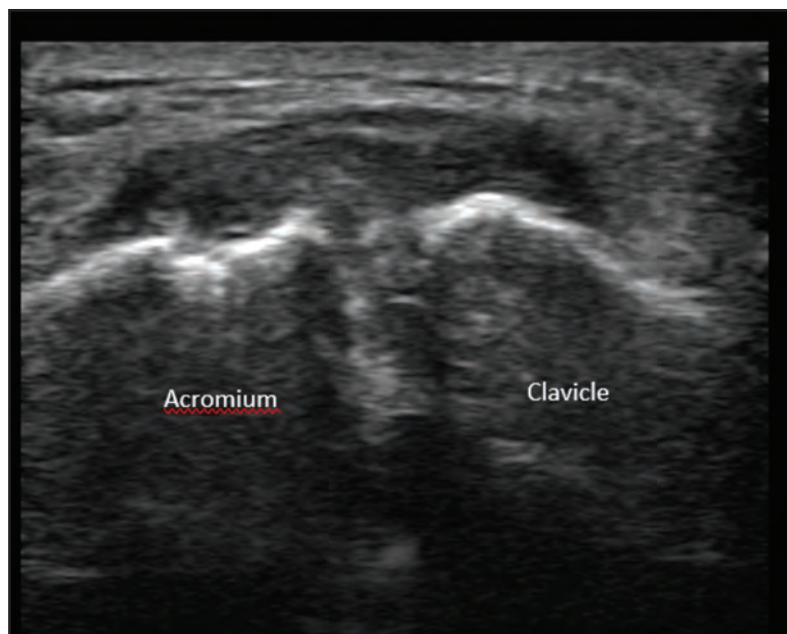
Bedside sports ultrasound demonstrated a large, well circumscribed swelling overlying the superior and anterior aspect of the acromioclavicular joint suggesting a possible effusion with mixed echogenic substance enclosed within the distended lesion. There was also presence of juxta-articular sclerotic margins.
